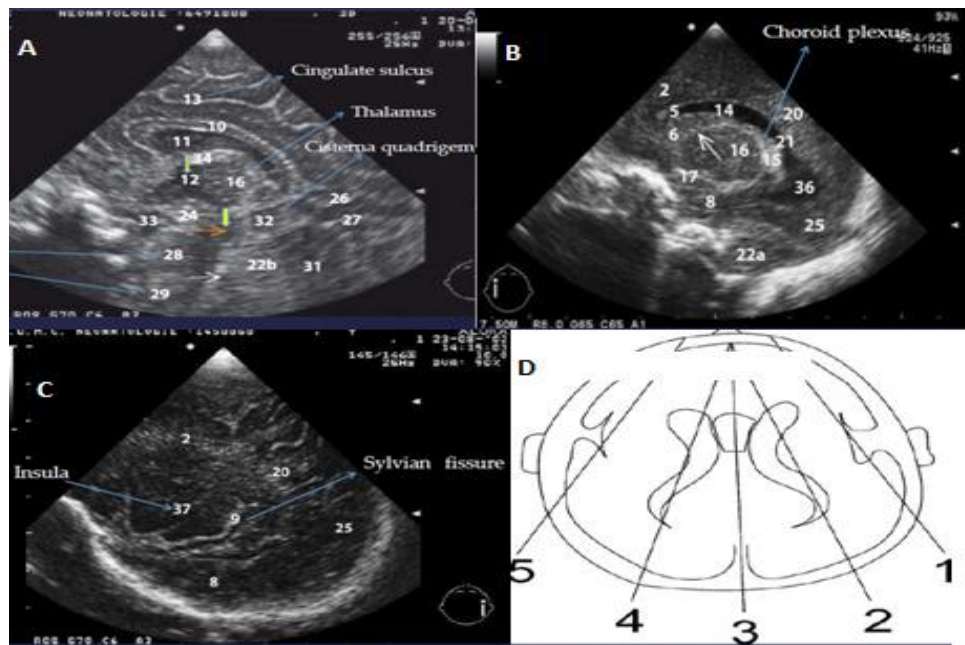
Ultrasound Images Showing the Three Left Hemisphere Standard Sagittal Planes for TCUS
